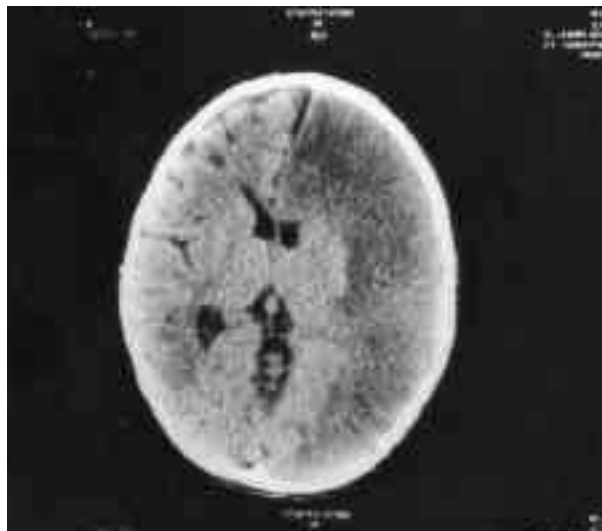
Cranial CT scan at the age of 11 months showing a massive infarction involving the left frontal, temporal, parietal, and occipital regions, sparing the left basal ganglia and thalamus.
